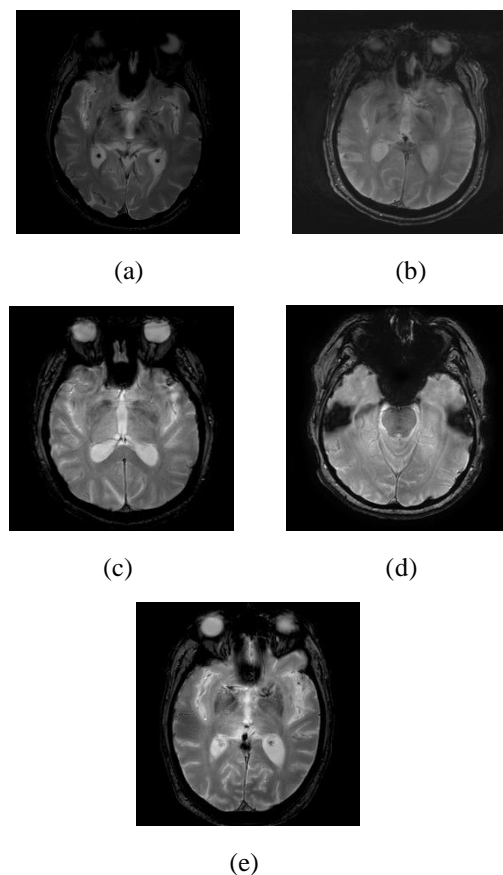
Brain MRI Images of 5 classes of Alzheimer's Disease
